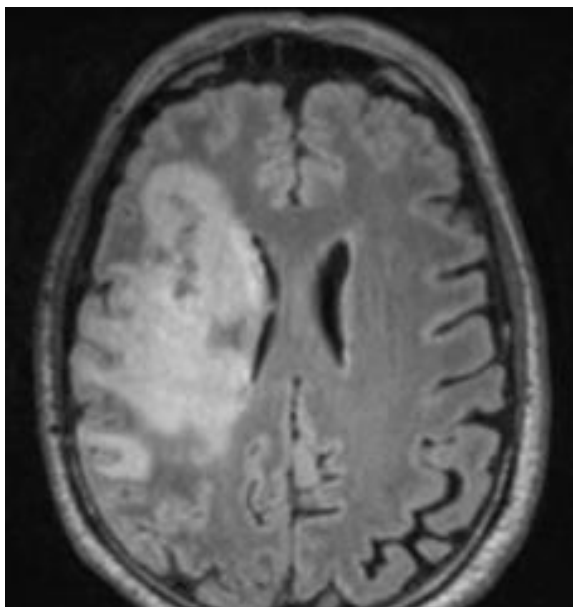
Examples of brain scan images of the same acute right hemisphere infarction, using different MRI sequences*
